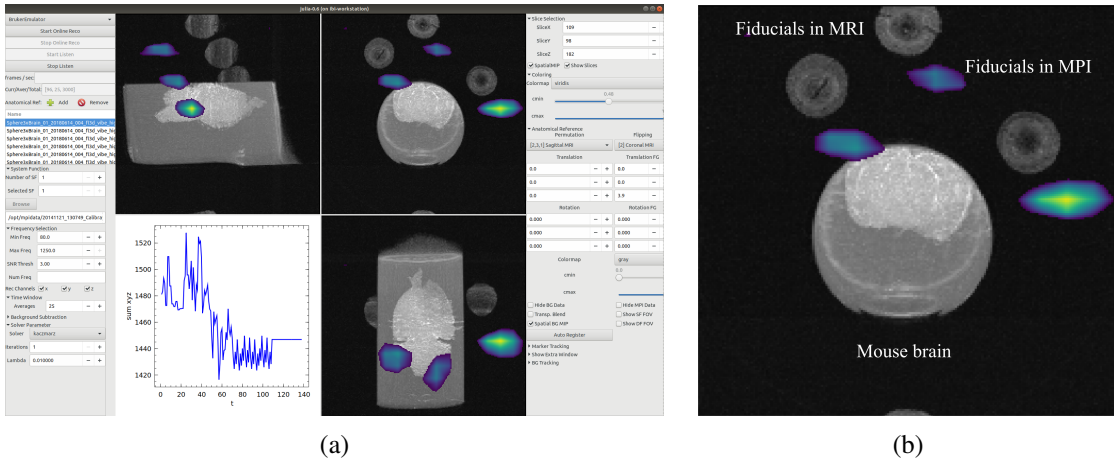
a) Extended online reconstruction software tool. Both images of MPI and MRI are not fully aligned yet. In the software, the registration parameters of the rotation matrix and translation vector between both images can be adjusted. Further, the reconstruction parameters and the visualization parameters can be adjusted during the experiment. b) Enlarged  $yz$ -slice of the data.
